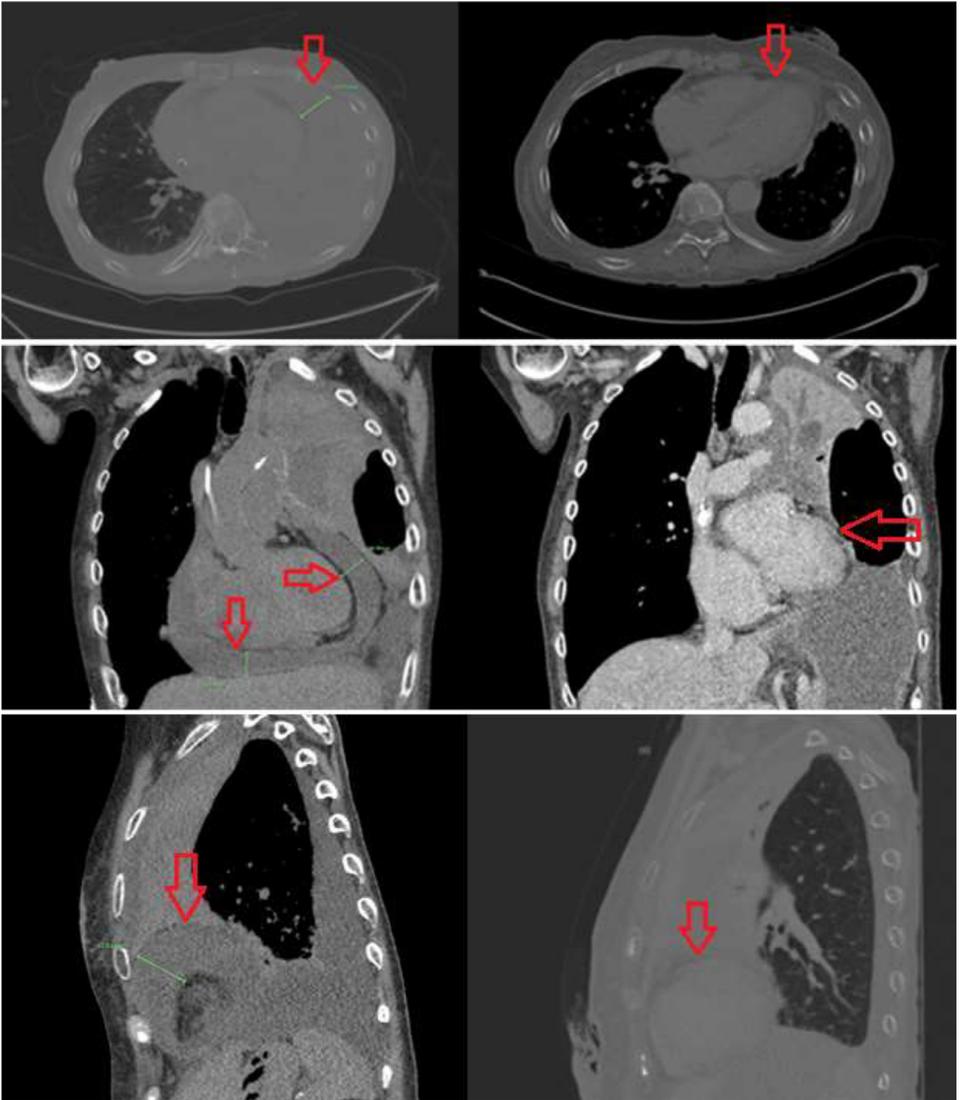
Axial (top), coronal (middle), and sagittal (bottom) helical CT scan images showing a large pericardial effusion (left) measuring up to 3.0 cm at the apex, which appears to have completely resolved (right) 9 days following drainage and steroid therapy.
